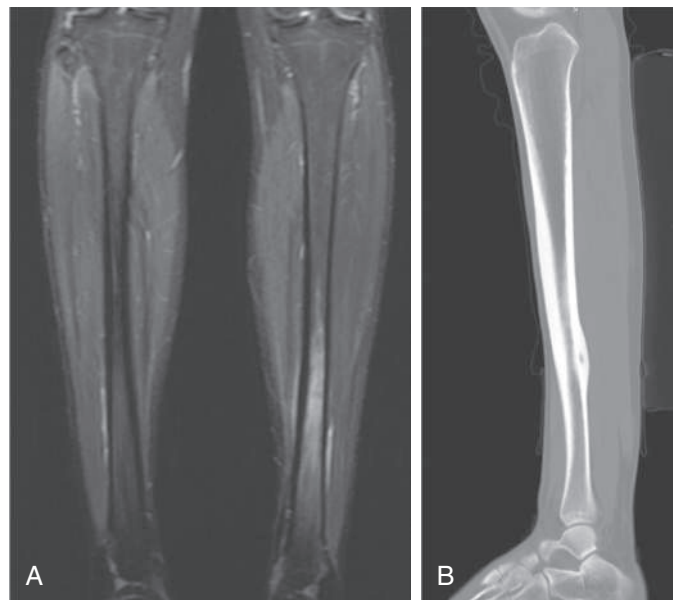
MRI and CT in 15-yr-old female with left tibial night pain. A, Coronal T2 weighted MR of the bilateral tibias shows increased T2 signal change in the left tibia diaphysis. B, Sagittal CT scan shows cortically based lesion <1 cm typical for osteoid osteoma. Patient was treated with percutaneous radiofrequency ablation.
